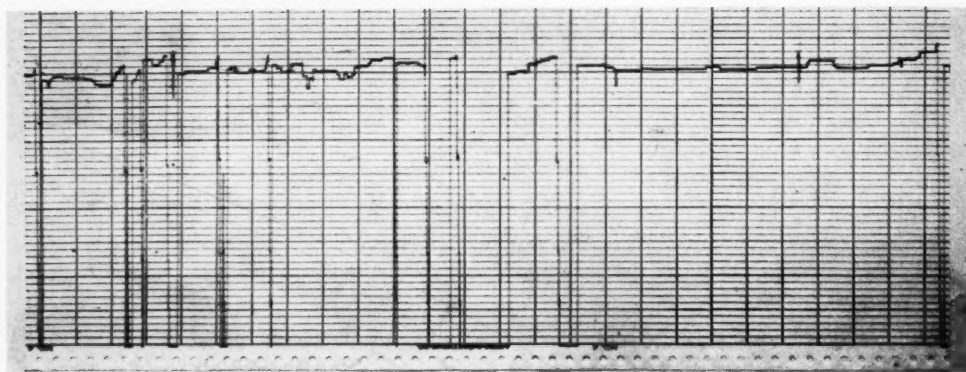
A graph indicating the intensity of X-rays emitted, as well as the periods and length of time of interruptions in the treatment.
